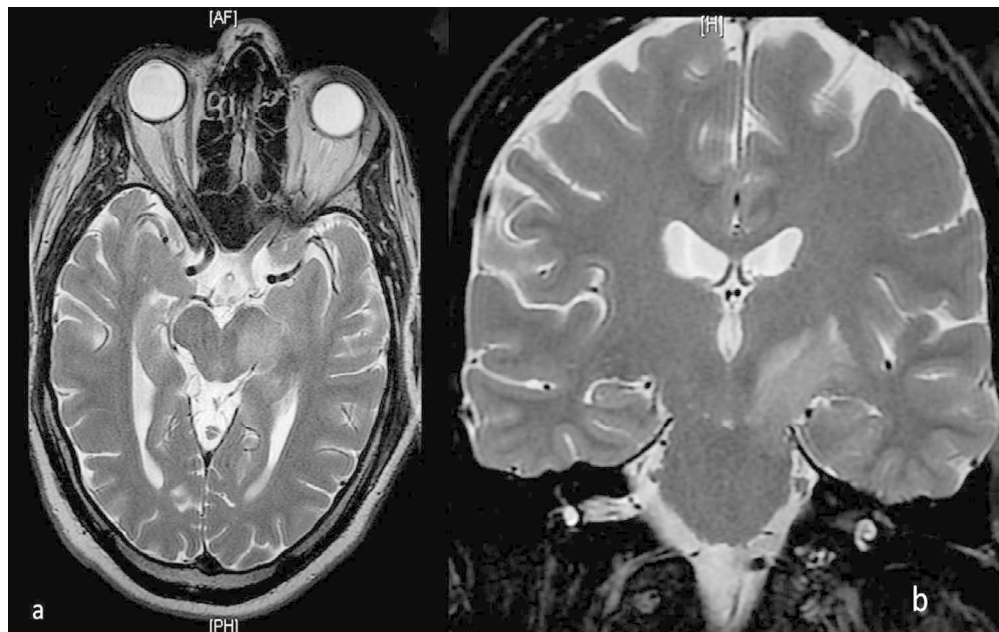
Horizontal (a) and coronal (b) T2-weighted MRI scans at presentation showing infiltration of left cerebral peduncle and internal capsule
